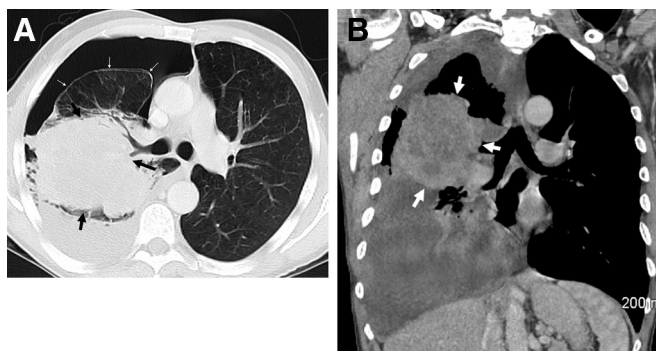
A, Axial computed tomography (CT) image through the upper lobes demonstrates a large mass in the right upper lobe (black arrows) obliterating the posterior segmental bronchus of the right upper lobe. There is a large right hydropneumothorax. Note the smooth visceral pleural thickening (white arrows) suggestive of visceral pleural tumor seeding. B, Coronal reformatted CT image obtained with contrast demonstrates the large right upper lobe tumor (white arrows) and the large right pleural effusion. No parietal pleural thickening or nodularity is identified.
